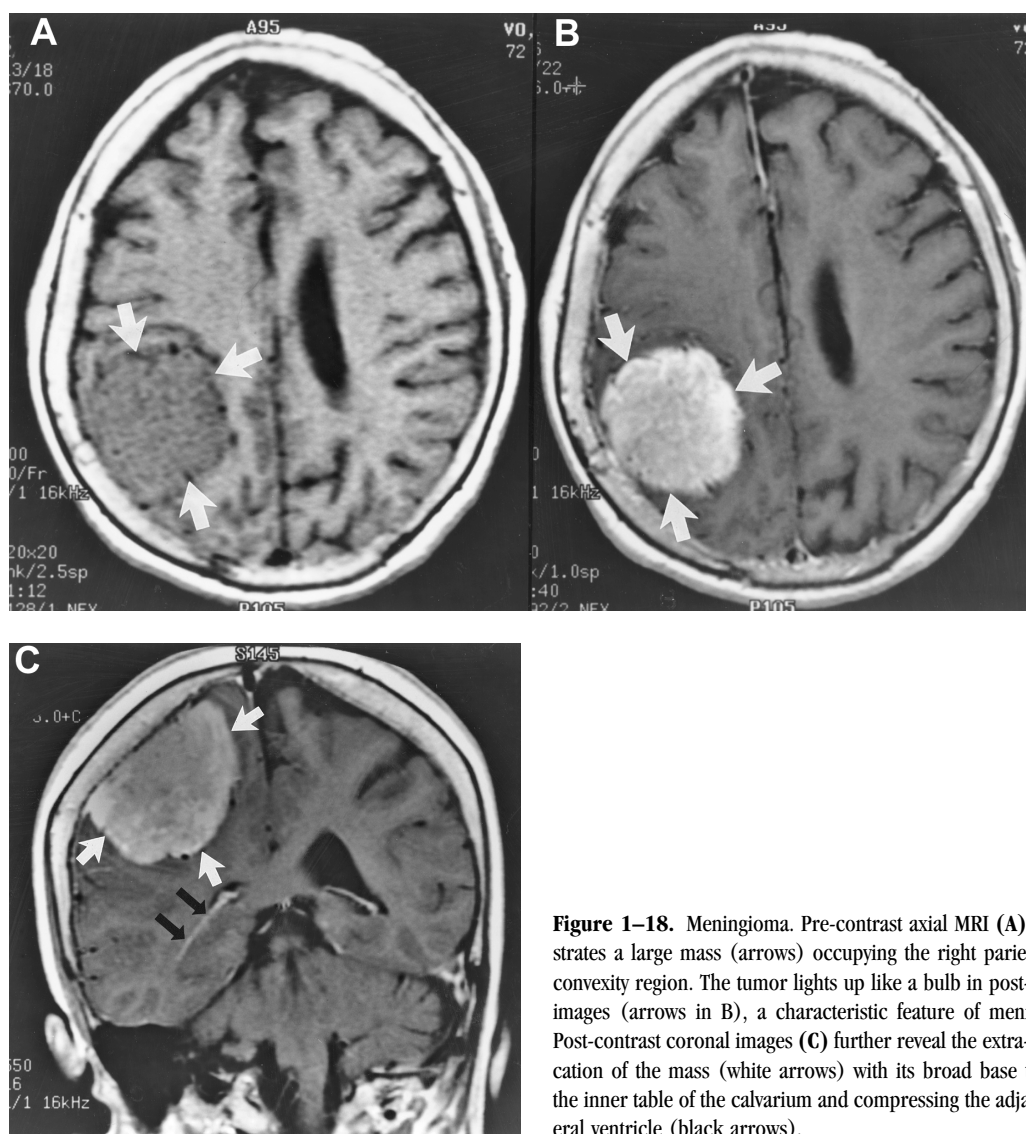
Meningioma. Pre-contrast axial MRI (A) demonstrates a large mass (arrows) occupying the right parietal high-convexity region. The tumor lights up like a bulb in post-contrast images (arrows in B), a characteristic feature of meningioma. Post-contrast coronal images (C) further reveal the extra-axial location of the mass (white arrows) with its broad base touching the inner table of the calvarium and compressing the adjacent lateral ventricle (black arrows).
